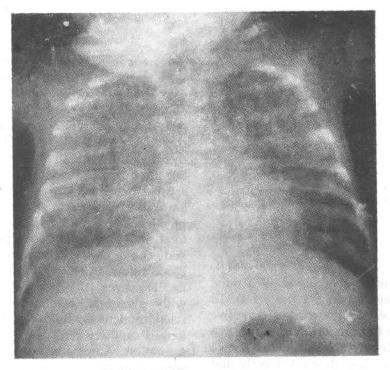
X-ray chest on day 49 showing bilateral mottling suggestive of miliary tuberculosis.
